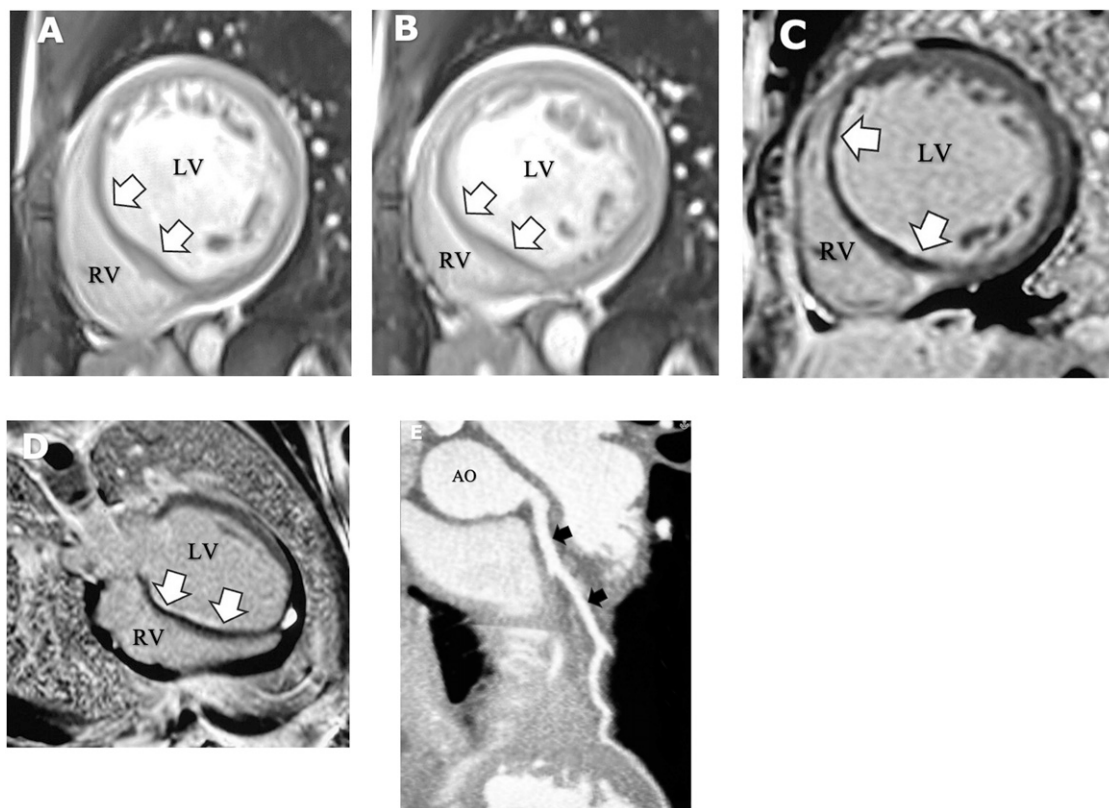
(a) Sagittal balanced steady-state free precession (SSFP) end-diastolic (A) short-axis views showed a dilated left ventricle (LV) and thinned interventricular septum (IVS) (arrows) with severe dyskinesia of the IVS raising concern for a possible chronic infarction. (b). Sagittal balanced steady-state free precession (SSFP) end-systolic (b) short-axis view showed a dilated left ventricle (LV) and thinned interventricular septum (IVS) (arrows) with severe dyskinesia of the IVS raising concern for a possible chronic infarction. (c) Late gadolinium enhanced (LGE) short-axis view demonstrated LGE in a subendocardial pattern along the IVS (arrows). (d) Late gadolinium enhanced (LGE) four-chamber view demonstrated LGE in a subendocardial pattern along the IVS (arrows). (e) CT coronary angiogram curved multiplanar reformat demonstrated a normal left anterior descending coronary artery with no atherosclerotic plaque (arrows) in the coronary artery. LGE findings were therefore attributed to left bundle branch block with pooling of gadolinium along the IVS.
